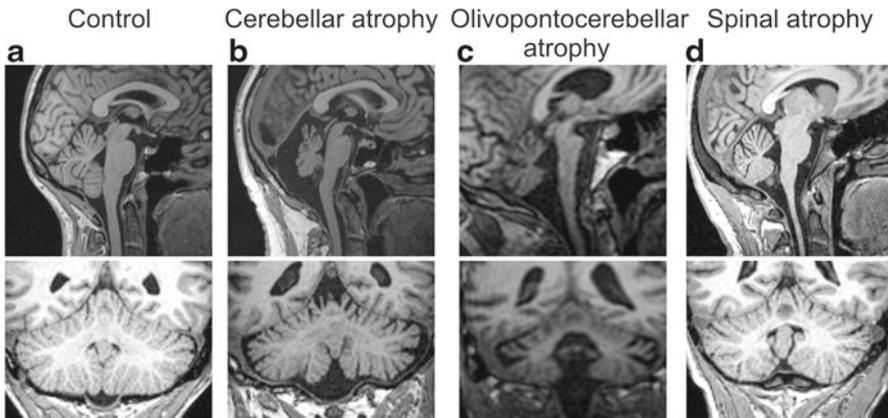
Characteristic MRI patterns of degenerative cerebellar ataxias based on T1 weighted images. Sagittal views are shown in the upper row, coronal views in the lower row. (a) Healthy control subject; (b) pure cerebellar atrophy in a patient with spinocerebellar ataxia type 6 (SCA6); (c) olivopontocerebellar atrophy (OPCA) in a patient with advanced spinocerebellar ataxia type 3 (SCA3), note accompanying atrophy of the spinal cord; (d) pure atrophy of the spinal cord in a patient with Friedreich ataxia
